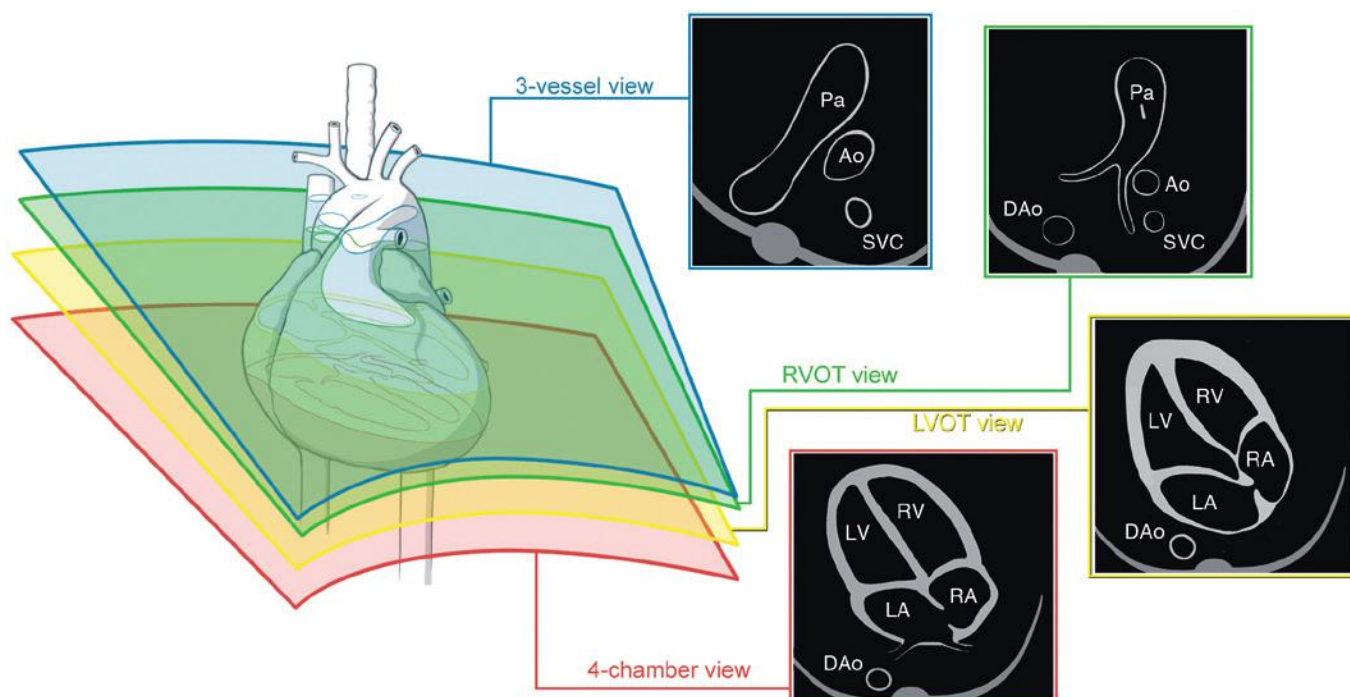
Sonographic scanning planes for fetal cardiac screening. The most inferior transverse plane is used to confirm that the stomach and heart are both on the left side of the fetus (not shown). A cephalad sweep of an ultrasound transducer toward the fetal head is used to visualize (1) four-chamber view; (2) left ventricular outflow tract (LVOT); (3) right ventricular outflow tract (RVOT); (4) and three-vessel view. Ao, ascending aorta; DAo, descending aorta; LA, left atrium; LV, left ventricle; Pa, pulmonary artery; RA, right atrium; RV, right ventricle; SVC, superior vena cava.
